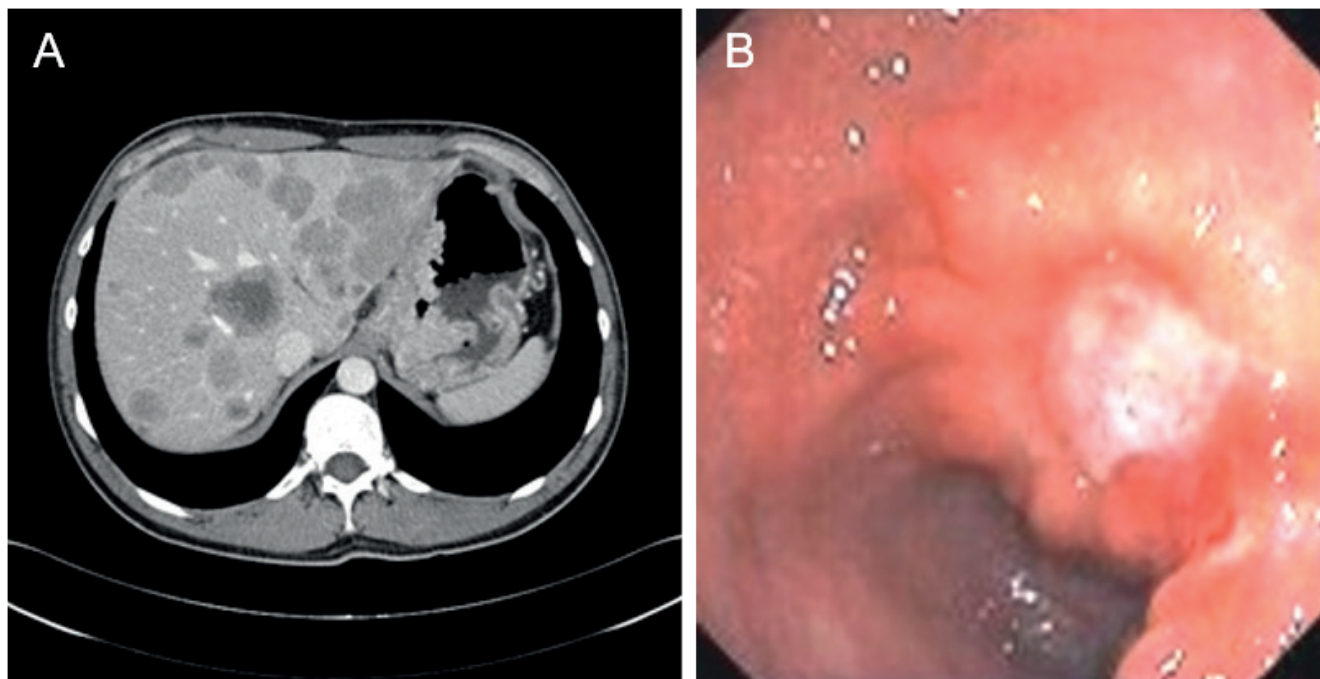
(A) Computed tomography scan showing multiple liver metastases, and (B) gastroscopy showing gastric cancer.
